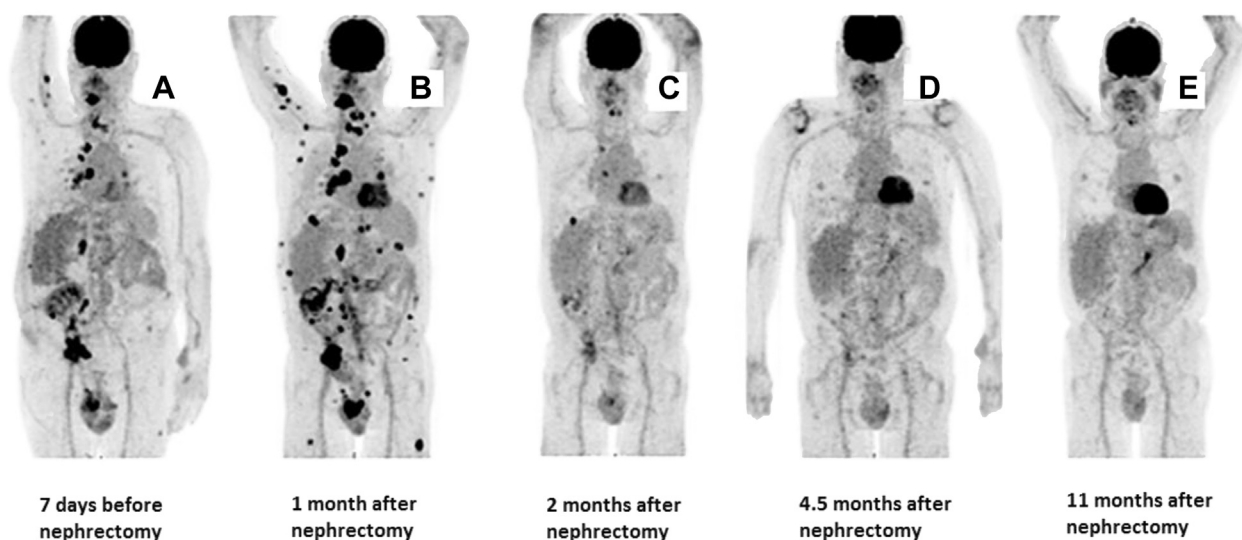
18F-FDG PET scan over time. (A) Diffuse thoracic lymph node metastases (in the peri-cardiac lipid tissue, at the hilus and mediastinum), multiple lesions in both lungs, and possibly a bone metastasis in the right scapula as well as hot spots in the oropharynx and thyroid gland. (B) Expansion of the tumor mass in the thorax, abdomen, upper and lower extremities, oropharynx, and mediastinum. New hot spots are seen in the para-iliac lymph nodes and liver. The mass in the testis and right groin remains stable. (C) Globally apparent but incomplete therapy response with still-active tracer activity in the mediastinum, right liver lobe, adrenal glands, and groin. (D) Complete remission. (E) No evidence of tumor re-occurrence (special thanks to Maarten Boer for helping with imaging).
